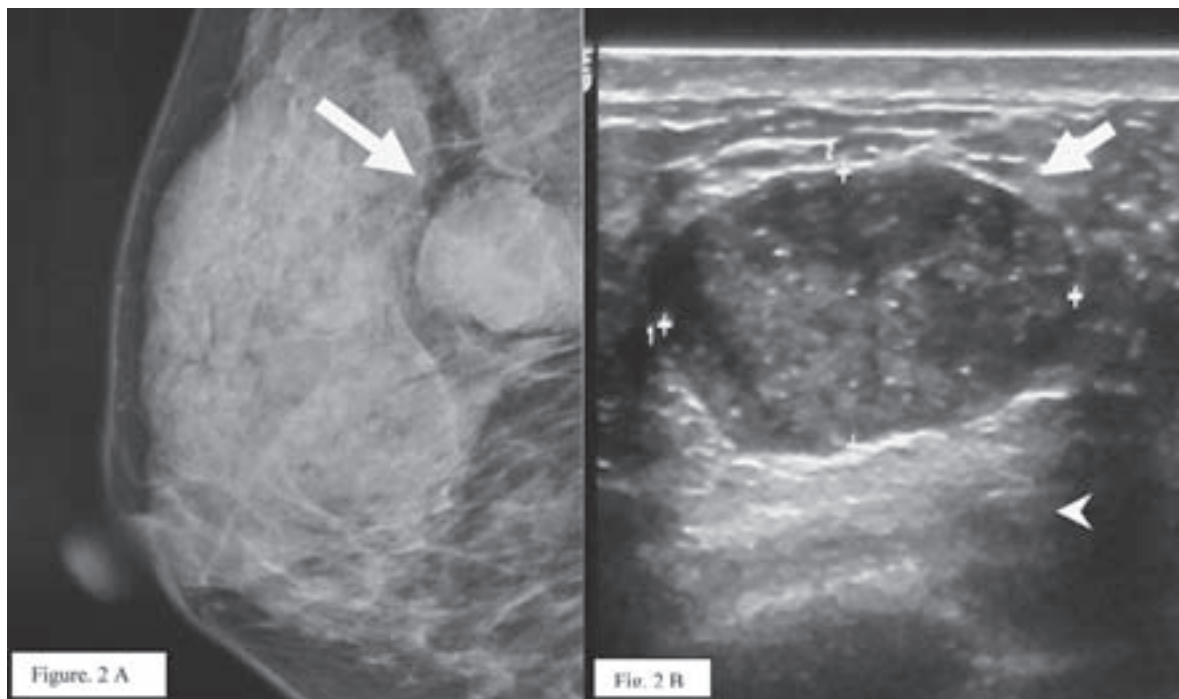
A 48 years old woman presented with a palpable right breast mass. Mammogram (Figure 2A) shows a macrolobulated mass at upper outer quadrant (arrow). Ultrasonogram (Figure 2B) demonstrated thin encapsulated mass (arrow) with area of posterior enhancement (arrowhead). BI-RADS 4 diagnosis was made. Pathologic diagnosis was fibroadenoma.
